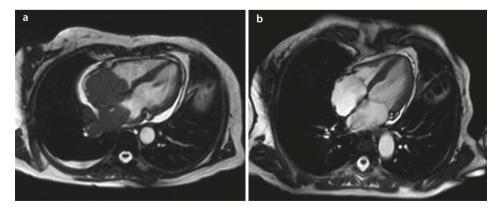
Magnetic resonance imaging in a case of primary cardiac non-Hodgkin lymphoma. a At diagnosis the mass occupied both atria, extending to pulmonary veins. b After R-CHOP chemotherapy there was complete remission
